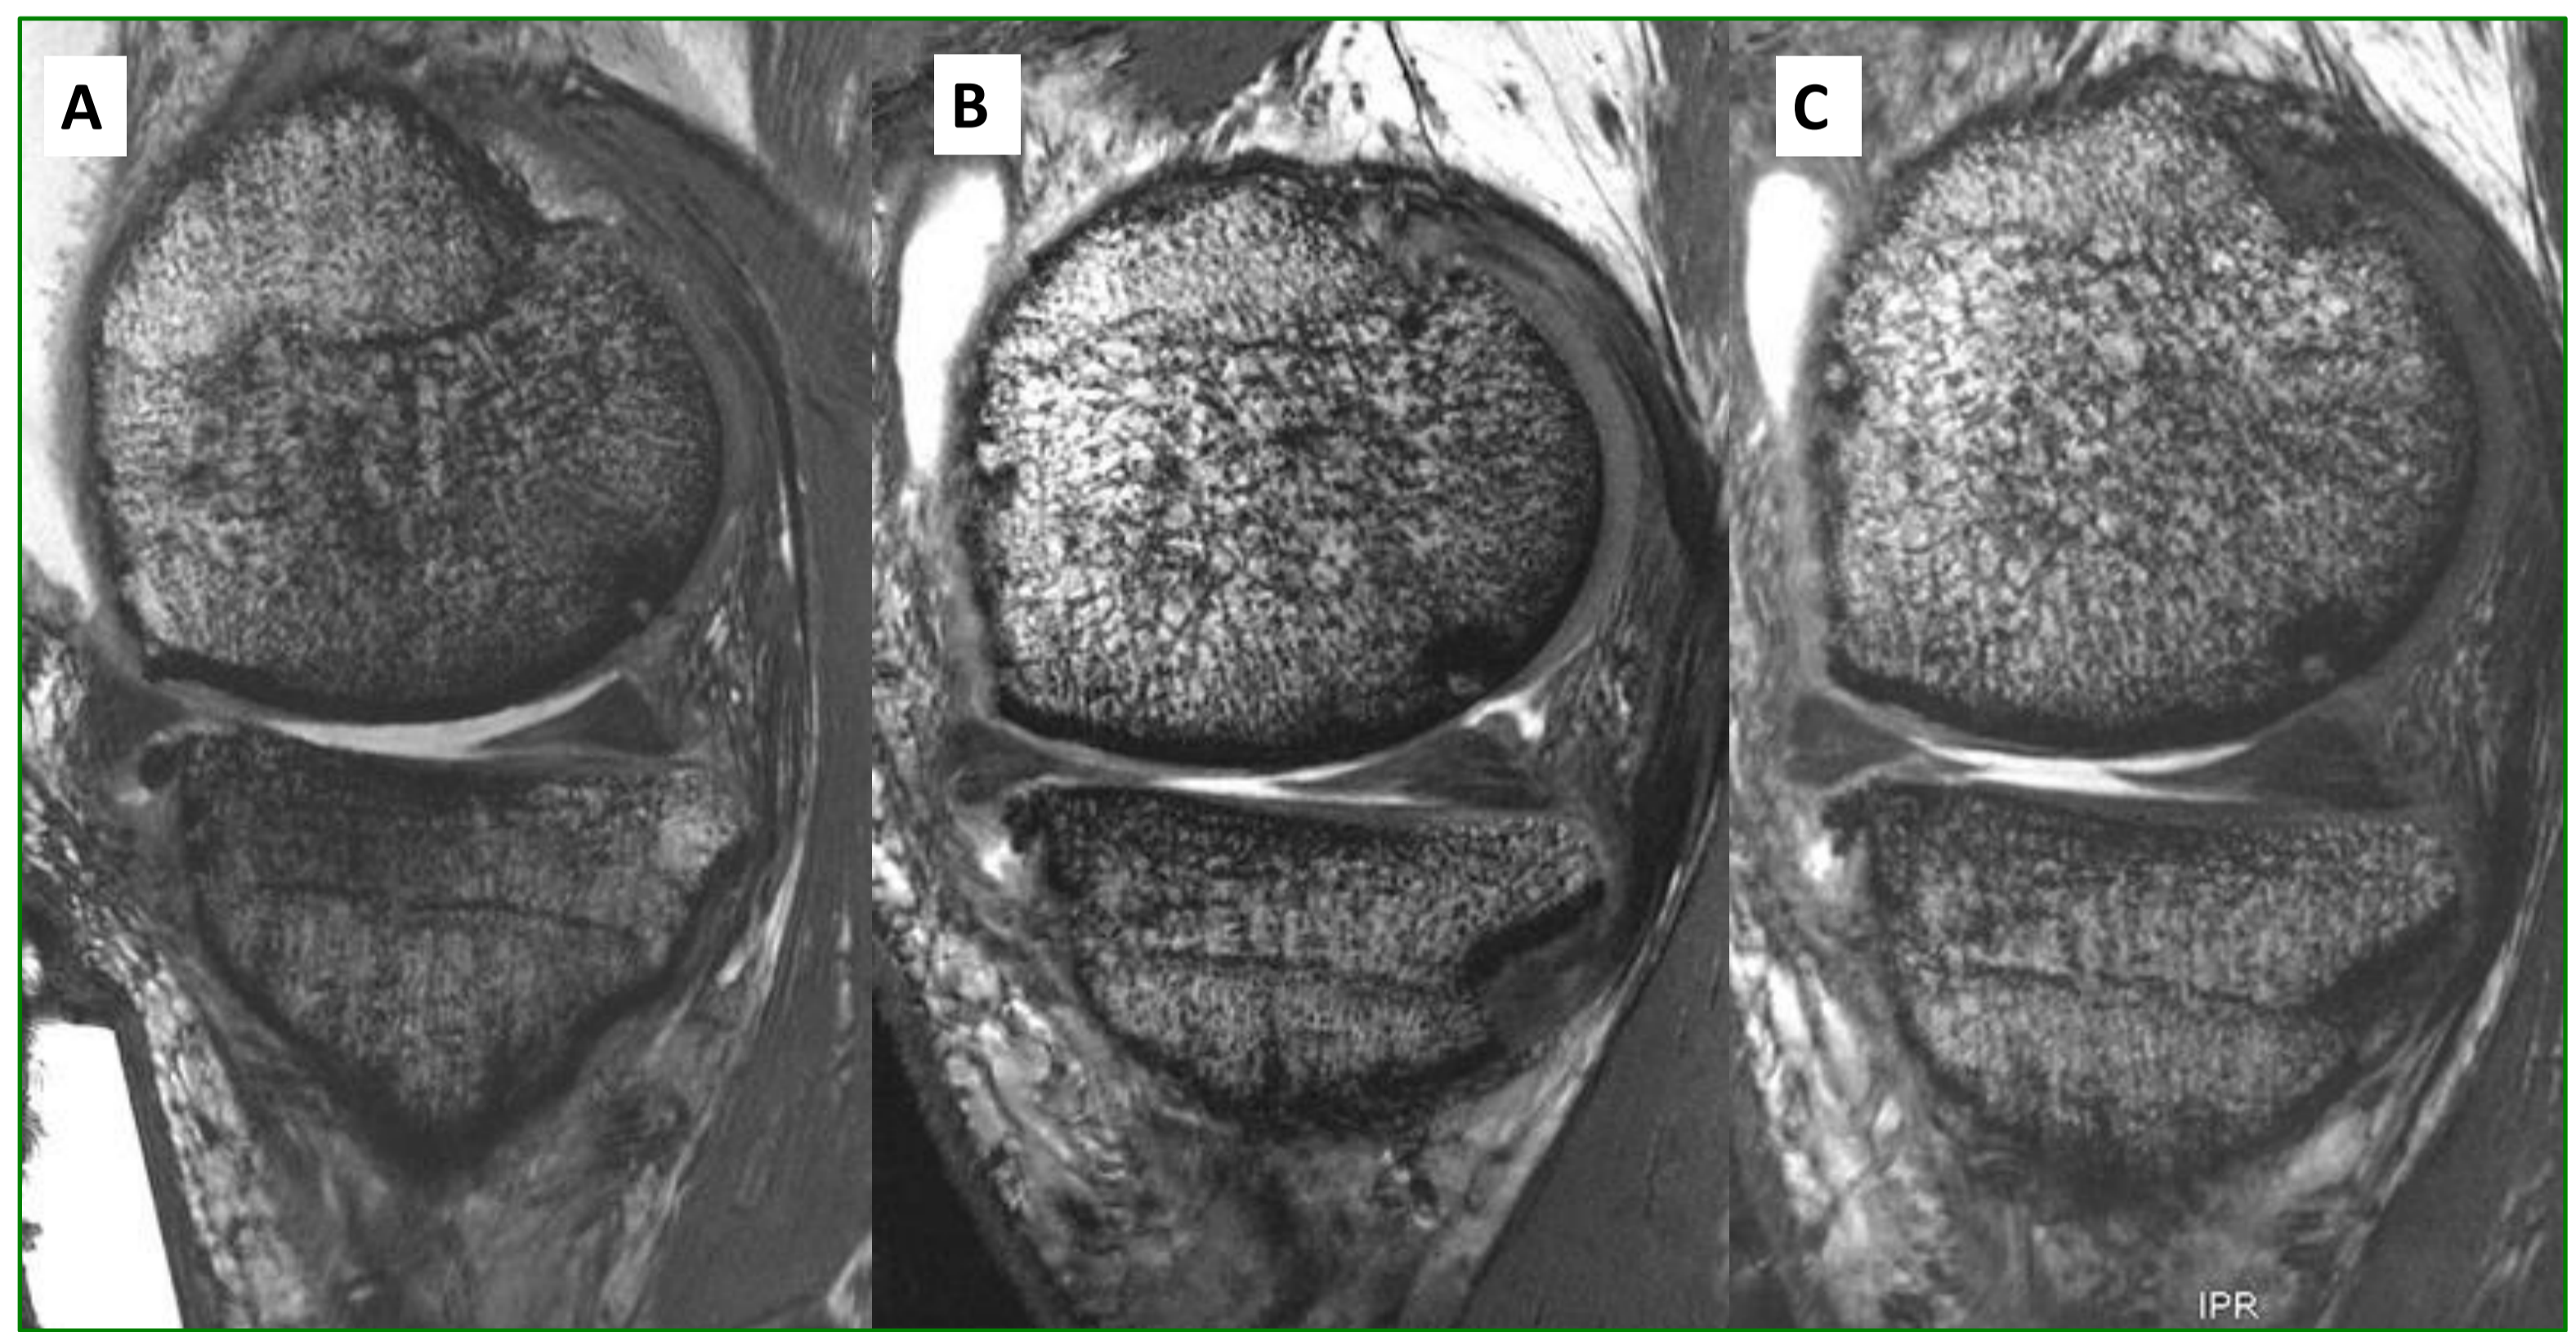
7T MRI of the knee showing cartilage thickness increase over the time: at V0 (A), V3 (B) and V4 (C).
